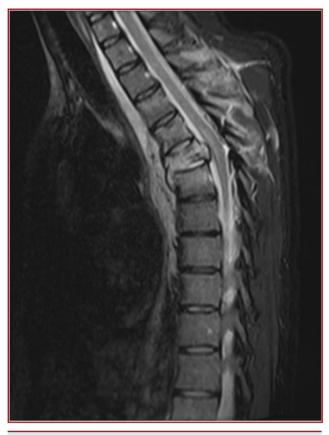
Preoperative T5 fracture sagittal MRI image
